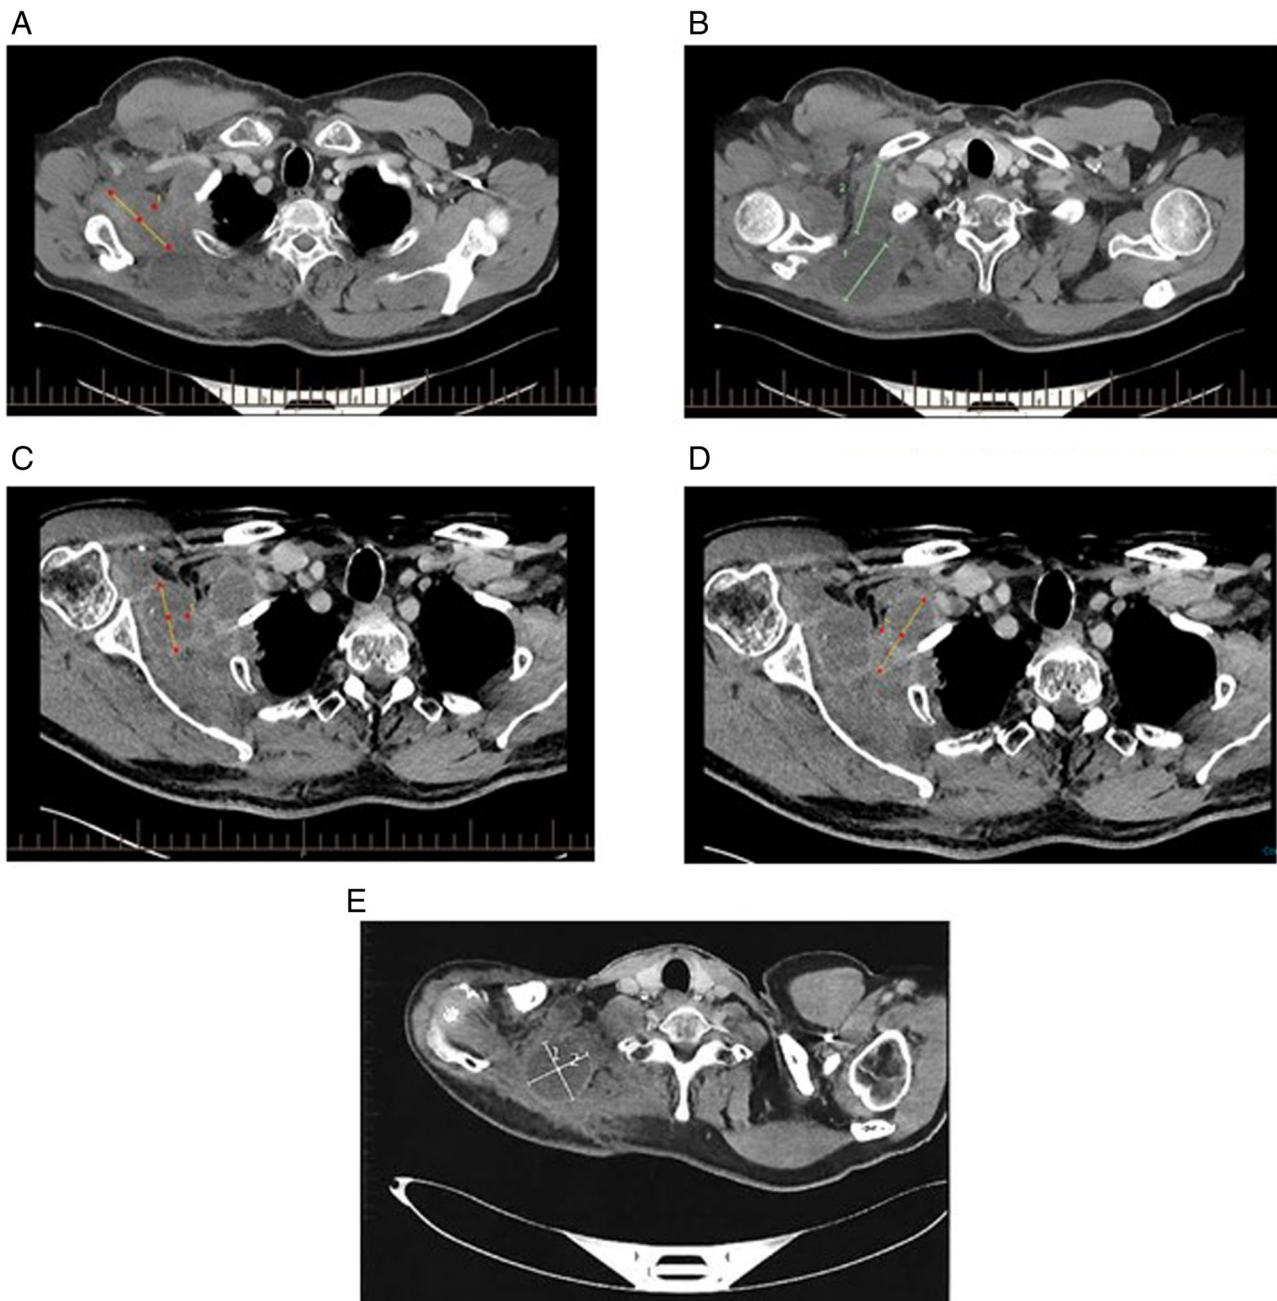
CT imaging of target lesions of Case 1 at baseline and after VG161 treatment. (A) CT scan of 1st target lesion at baseline. (B) CT scan of 2nd and 3rd target lesions at baseline. (C) CT scans of 1st target lesion on C5D28. (D) CT scans of 2nd target lesion on C5D28. (E) CT scans of 3rd target lesion on C5D28. CT, computed tomography.
